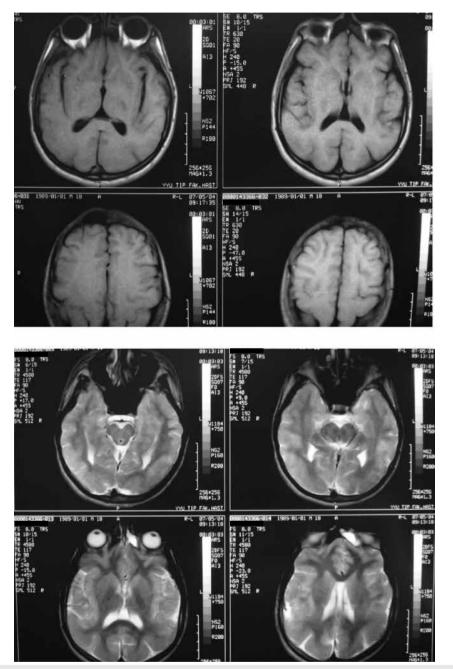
Cranial MRI demonstrated decreased number and depth of cortical sulci in both hemispheres which was emphasized in the parieto-occipital region, and reduced white matter volume.
